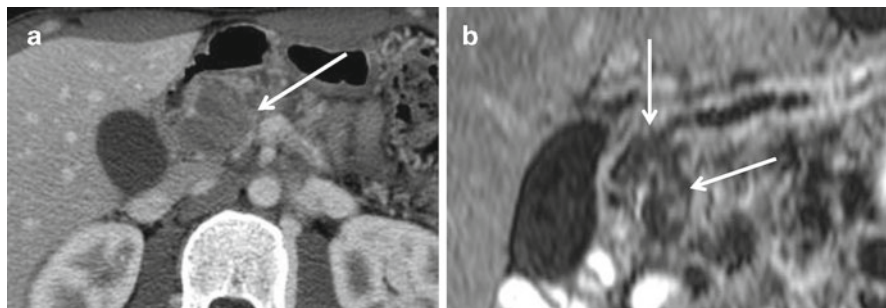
Acinar cell carcinoma growing in the pancreatic duct. (a) The portal venous phase of axial MDCT shows hypoattenuating mass in the pancreatic head (*arrow*). (b) Post-contrast curved planar reformatted image of dynamic MRI demonstrates the tumor to be confined in the main pancreatic and branch ducts (*arrows*)
